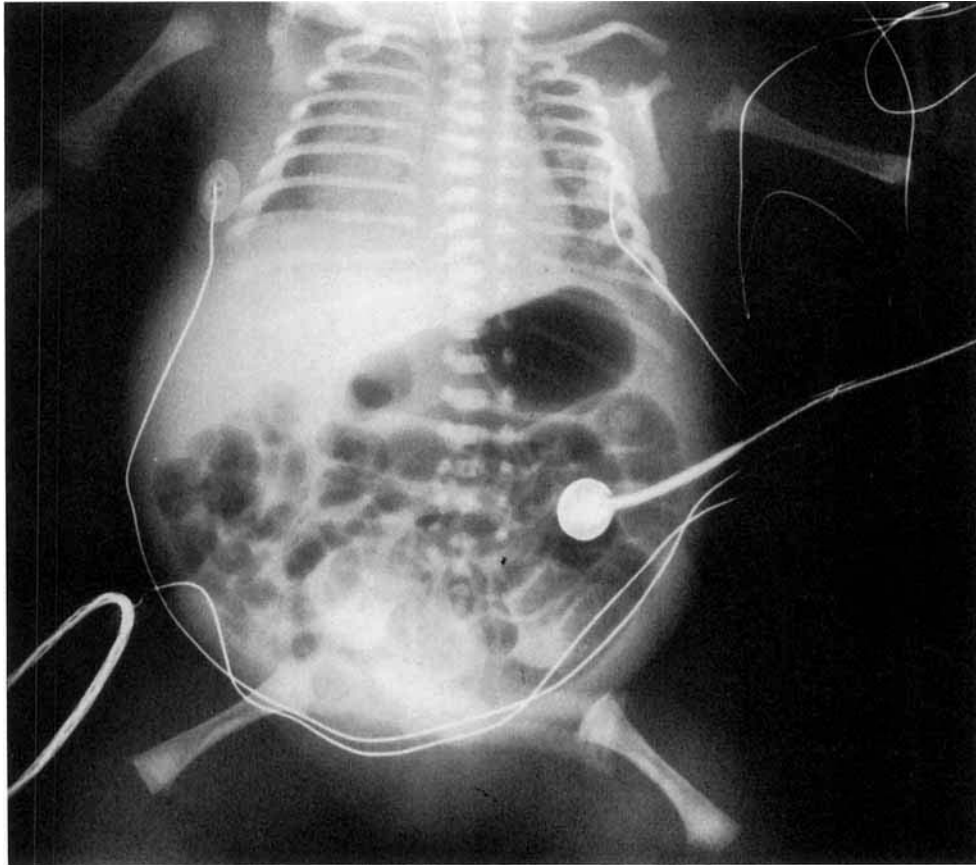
Radiograph of the proband.
